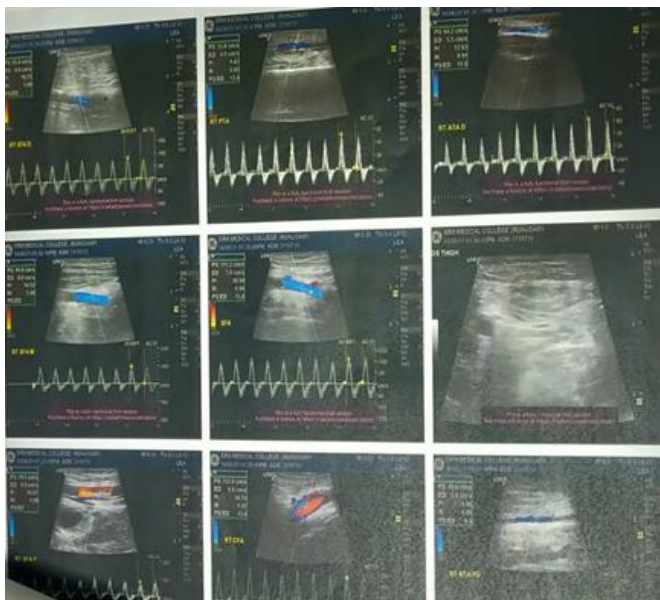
Doppler of Right Lower limb Showing obstruction of flow
